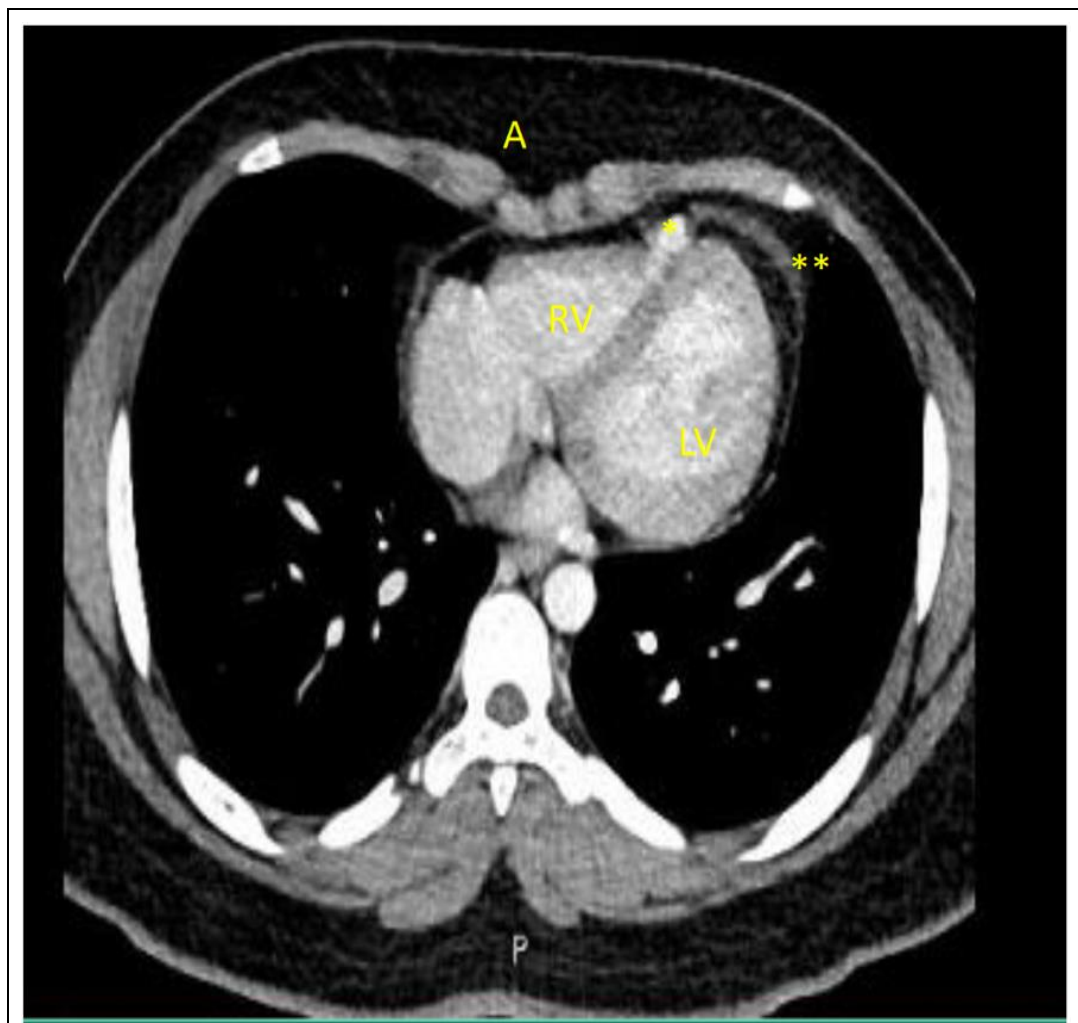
Transverse CT slice: A -anterior, LV-left ventricle, P-posterior, RV-right ventricle, * pseudoaneurysm,  pericardial effusion.
